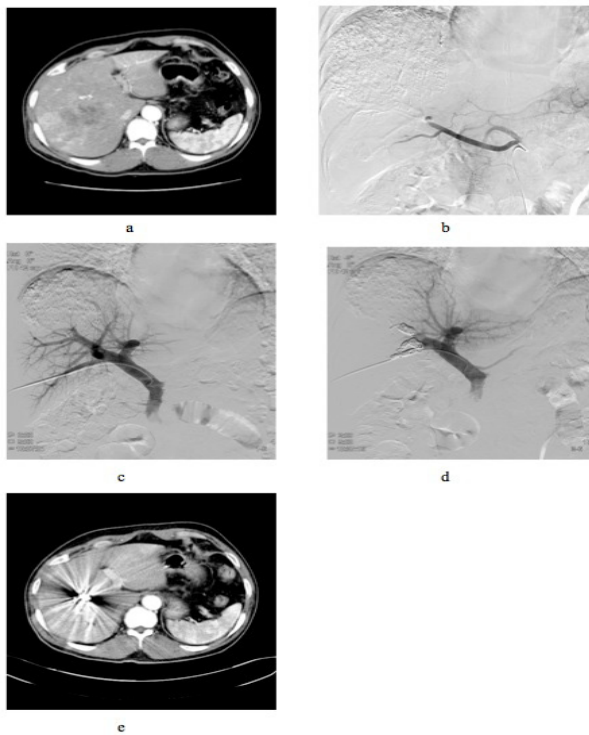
Patient: Man, 65 Years, HCC. a. FRL volumes were measured by computed tomography(CT) volumetry before TACE. %FLR-pre is about 28.7%. b.TACE: Lipiodol and Epirubicin hybrid emulsion was infused into the selected segmental feeding artery until arterial flow stasis achieved. c-d. PVE: Two weeks after TACE when recovery of liver function, PVE was performed using the ipsilateral percutaneous approach. e. Computed tomography(CT) scans were performed three weeks after PVE to measure the volumes of the total liver, the part planned to be resected, total tumor volume, and the FRL. The tumor volume didn't change so much, but the FRL volume increase almost 41.4% compared with before TACE. The %FLR-pre is about 40.2%
